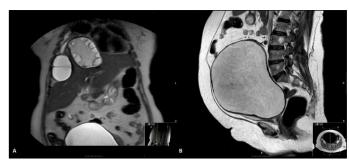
Abdominal magnetic resonance imaging. A. Two hydatid cysts lesions of the liver. B. Giant cystic lesion which fills uterine space.
